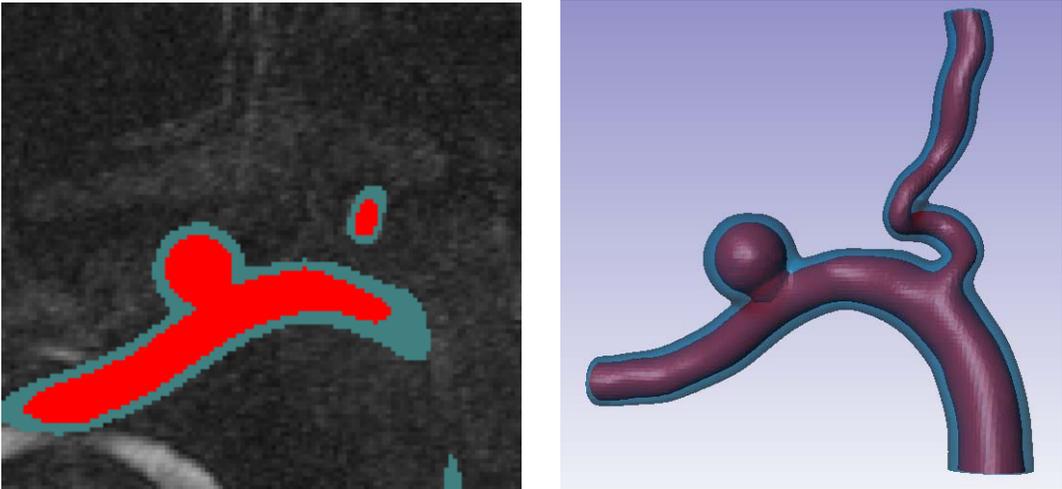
A more realistic computational model: (left) one of the images in the CT source dataset; (right) the 3D solid model of the aneurysm obtained by imagistic techniques
